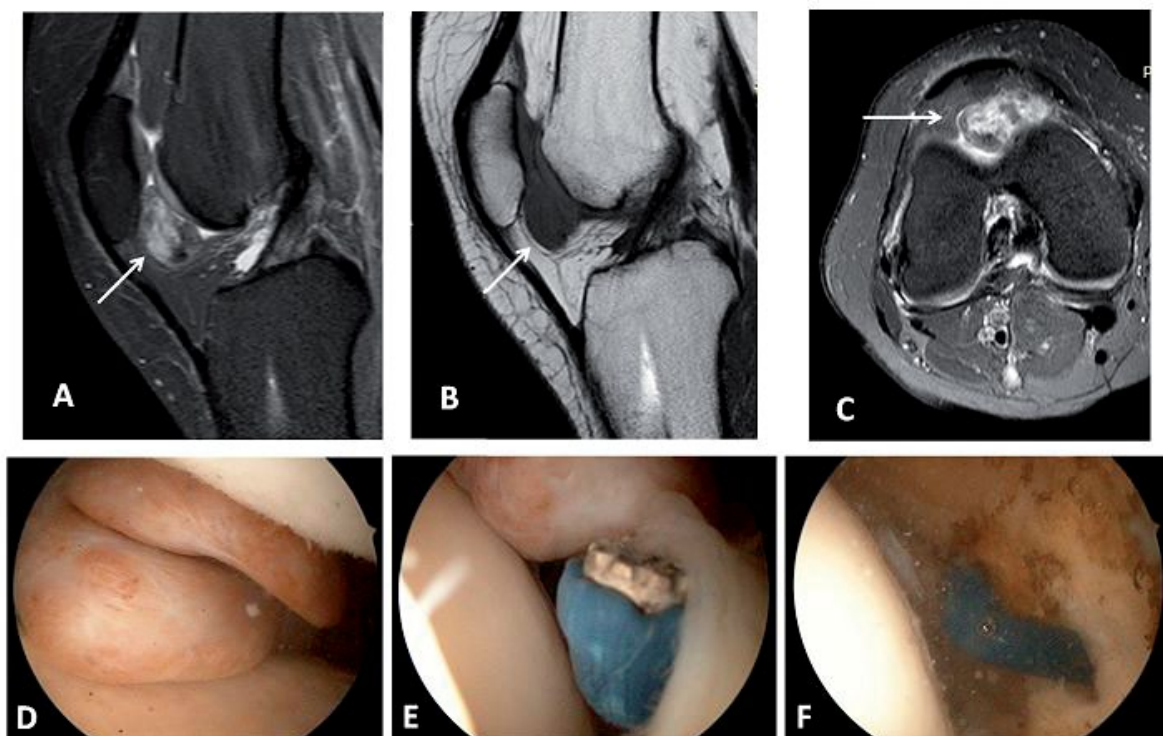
Case 10, a 44-year-old female patient: (A) sagittal view on magnetic resonance image (MRI) with PD-FS technique with the arrow pointing at the well-defined, lobulated isointense lesion localized in the intercondylar notch; (B) sagittal view on MRI with T1-FS technique with the arrow pointing at the well-defined, lobulated isointense lesion localized in the intercondylar notch; (C) axial view on MRI with PD-FS technique with the arrow pointing at the well-defined, lobulated isointense lesion localized in the intercondylar notch; (D) arthroscopic view from the anterolateral portal showing a nodule of pigmented villonodular synovitis; (E) arthroscopic view from the anterolateral portal showing resection of the nodule from its stalk with a radiofrequency wand. The radiofrequency wand is placed into the knee through the anteromedial portal; (F) arthroscopic view from the anterolateral portal after partial synovectomy of the area surrounding the base of the lesion.
